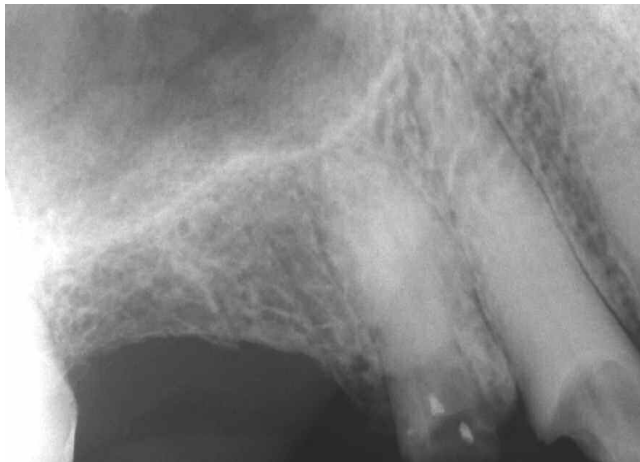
My 1983 pre-op radiographic image reveals coronally broken down and endodontically involved teeth #s 5 and 6.
